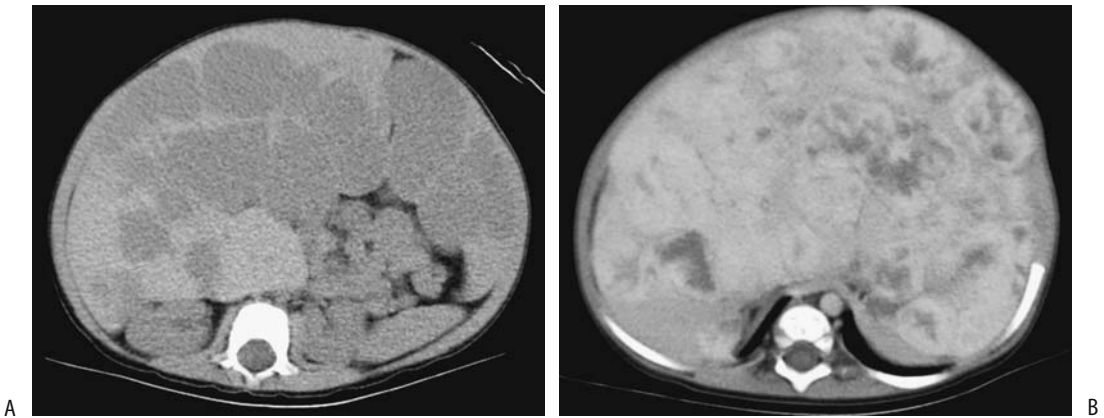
Liver hemangioendotheliosis in a 1-year-old girl. She also has skin hemangiomas and has mild congestive heart failure. A: Precontrast CT reveals an extensive blood density infiltrate involving large portions of the liver. B: Contrast-enhanced CT shows a heterogeneous tumor mostly isodense with liver. Of note is the small caliber aorta. (Courtesy of Luann Teschmacher, M.D., University of Rochester.)
